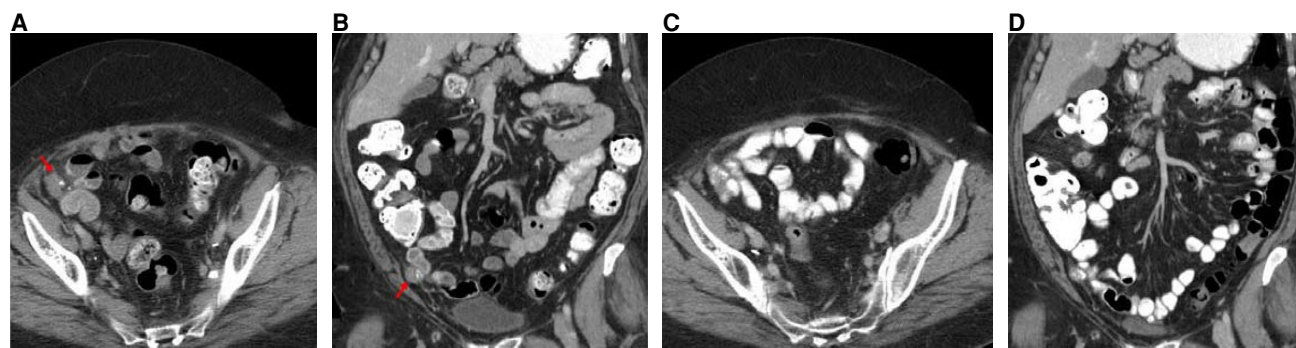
CT scans of the abdomen and pelvis with contrast prior to initiation of an FGFR inhibitor on trial. (A) Axial CT image with oral and intravenous contrast at the level of the mid pelvis shows a 3-cm soft tissue mass with minimal calcifications (red arrow). (B) Coronal reconstructed CT image with oral and intravenous contrast through the anterior abdomen and pelvis shows the 3-cm soft tissue mass with minimal calcifications (red arrow). CT scans of the abdomen and pelvis with contrast obtained during treatment with FGFR inhibitor on trial. (C) Axial CT image with oral and intravenous contrast at the level of the mid pelvis shows no measurable mass. (D) Coronal reconstructed CT image with oral and intravenous contrast through the anterior abdomen and pelvis shows no measurable mass.
